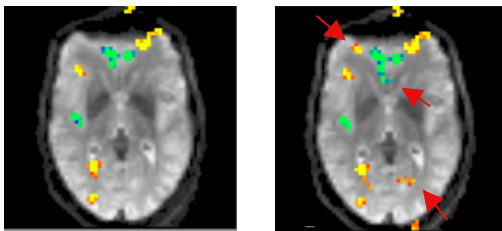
Un-weighted (left) and weighted summation based on FLAIR T_2^* map (right). Arrows indicate clusters only visible with pixel-wise echo weighting ($acc=2$).
